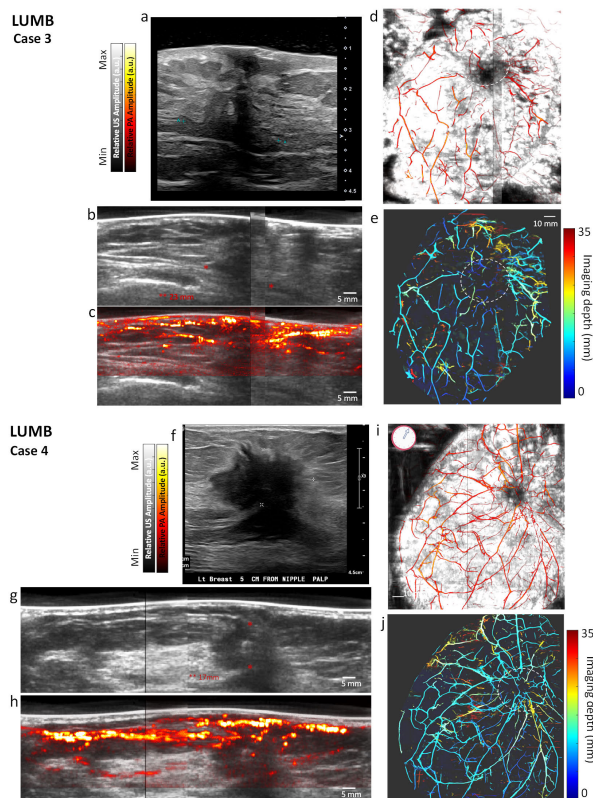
OneTouch-PAT imaging results of two LUMB cases. a & f represent the clinical ultrasound image. b & g represent the one-touch ultrasound (gray) images. c, h represent the photoacoustic (color) images overlaid on top of US images. d & i represent the 3D projection PA overlaid on top of US images (frontal view of the breast). e & j represent the depth-encoded 3D projection PA images (frontal view of the breast).
